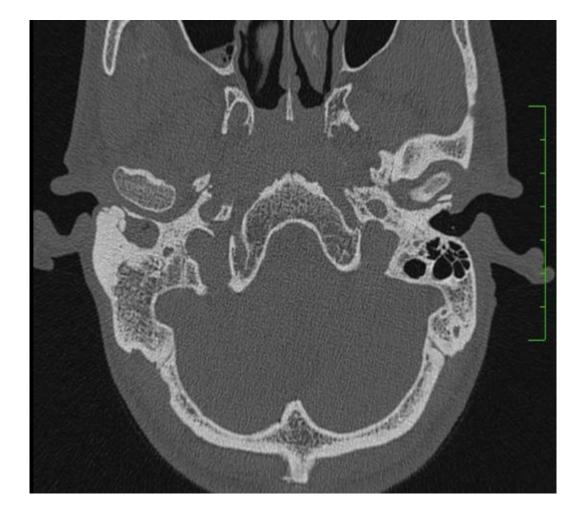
Exostoses of the EAC.HRCT axial image shows a broad based exostosis (thin arrow) causing obliteration of the right EAC with retained secretions in the external auditory canal (block arrow). Few other smaller bony exostoses are also seen further compromising the right EAC (curved down arrow). Sclerosis of the right mastoid is also seen.
